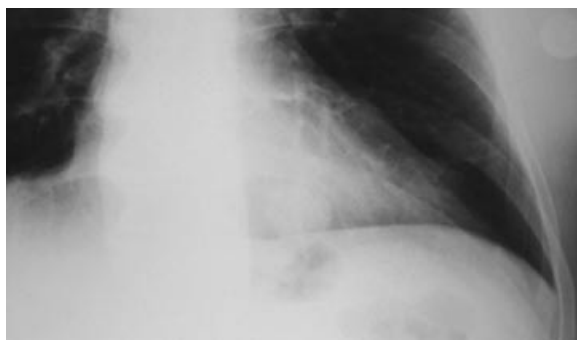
Pulmonary hamartoma on the chest X-ray in difficult to diagnose location.
